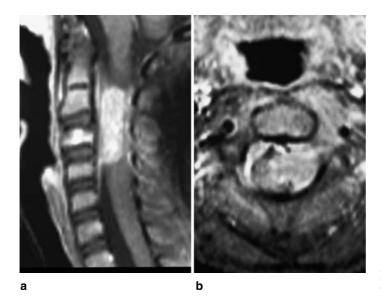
MRI reveals an extradural tumour at the spinal level C2-4, which displaces the spinal cord laterally
